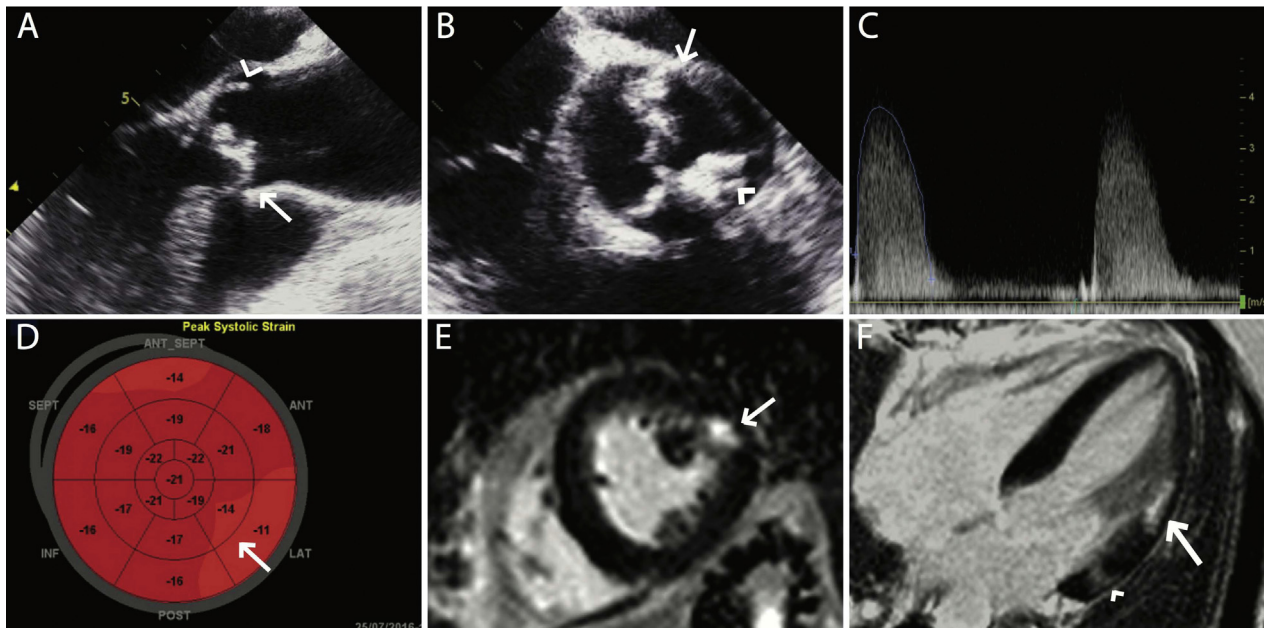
Echocardiographic and CMR images. (A) Transesophageal echocardiography (TEE). Two-dimensional midesophageal view of the aortic valve at 120° in systole showing good opening of the leaflet posteriorly (*arrowhead*) but heavy restriction and calcification anteriorly (*arrow*). (B) TEE. Two-dimensional midesophageal short-axis view of the aortic valve showing a posteriorly located opening orifice with a single commissure between the left and noncoronary cusps (*arrow*), two visible raphes anteriorly, and heavy calcification on the anterior aspect of the leaflet (*arrowhead*). (C) Transthoracic echocardiography. Continuous-wave Doppler in the right parasternal window showed a Vmax of 3.8 m/s and a mean gradient of 38 mm Hg. (D) Longitudinal strain analysis showing reduced deformation in the anterolateral basal (*arrow*) and midventricular wall, with GLS of -17.6% . (E) CMR, midventricular short-axis view. Late inversion-recovery sequences after gadolinium injection showed a focal area of enhancement (*arrow*) suggesting myocardial replacement fibrosis. (F) CMR, four-chamber view. Late inversion-recovery sequences after gadolinium injection showed two focal areas of predominantly midwall enhancement, the largest one extending over 22 mm in the midanterolateral wall (*arrow*) and a smaller one at the basal level (*arrowhead*), suggesting myocardial replacement fibrosis. ANT, Anterior; ANT-SEPT, antero-septal; INF, inferior; LAT, lateral; POST, posterior; SEPT, septal.
